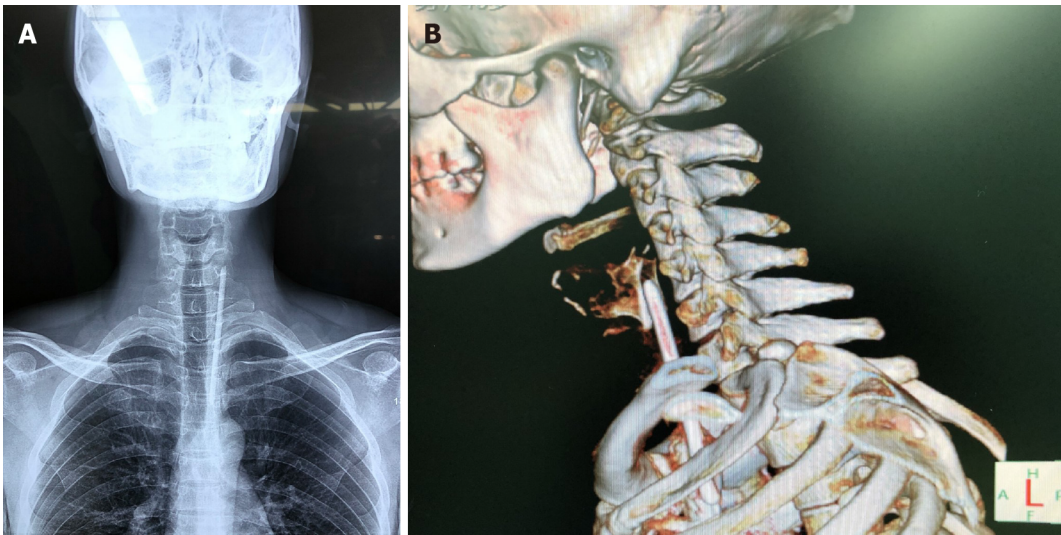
Rod-shaped foreign body extending from the left pyriform sinus to the mediastinum. A: X-ray plain film; B: Three-dimensional reconstructive image.
